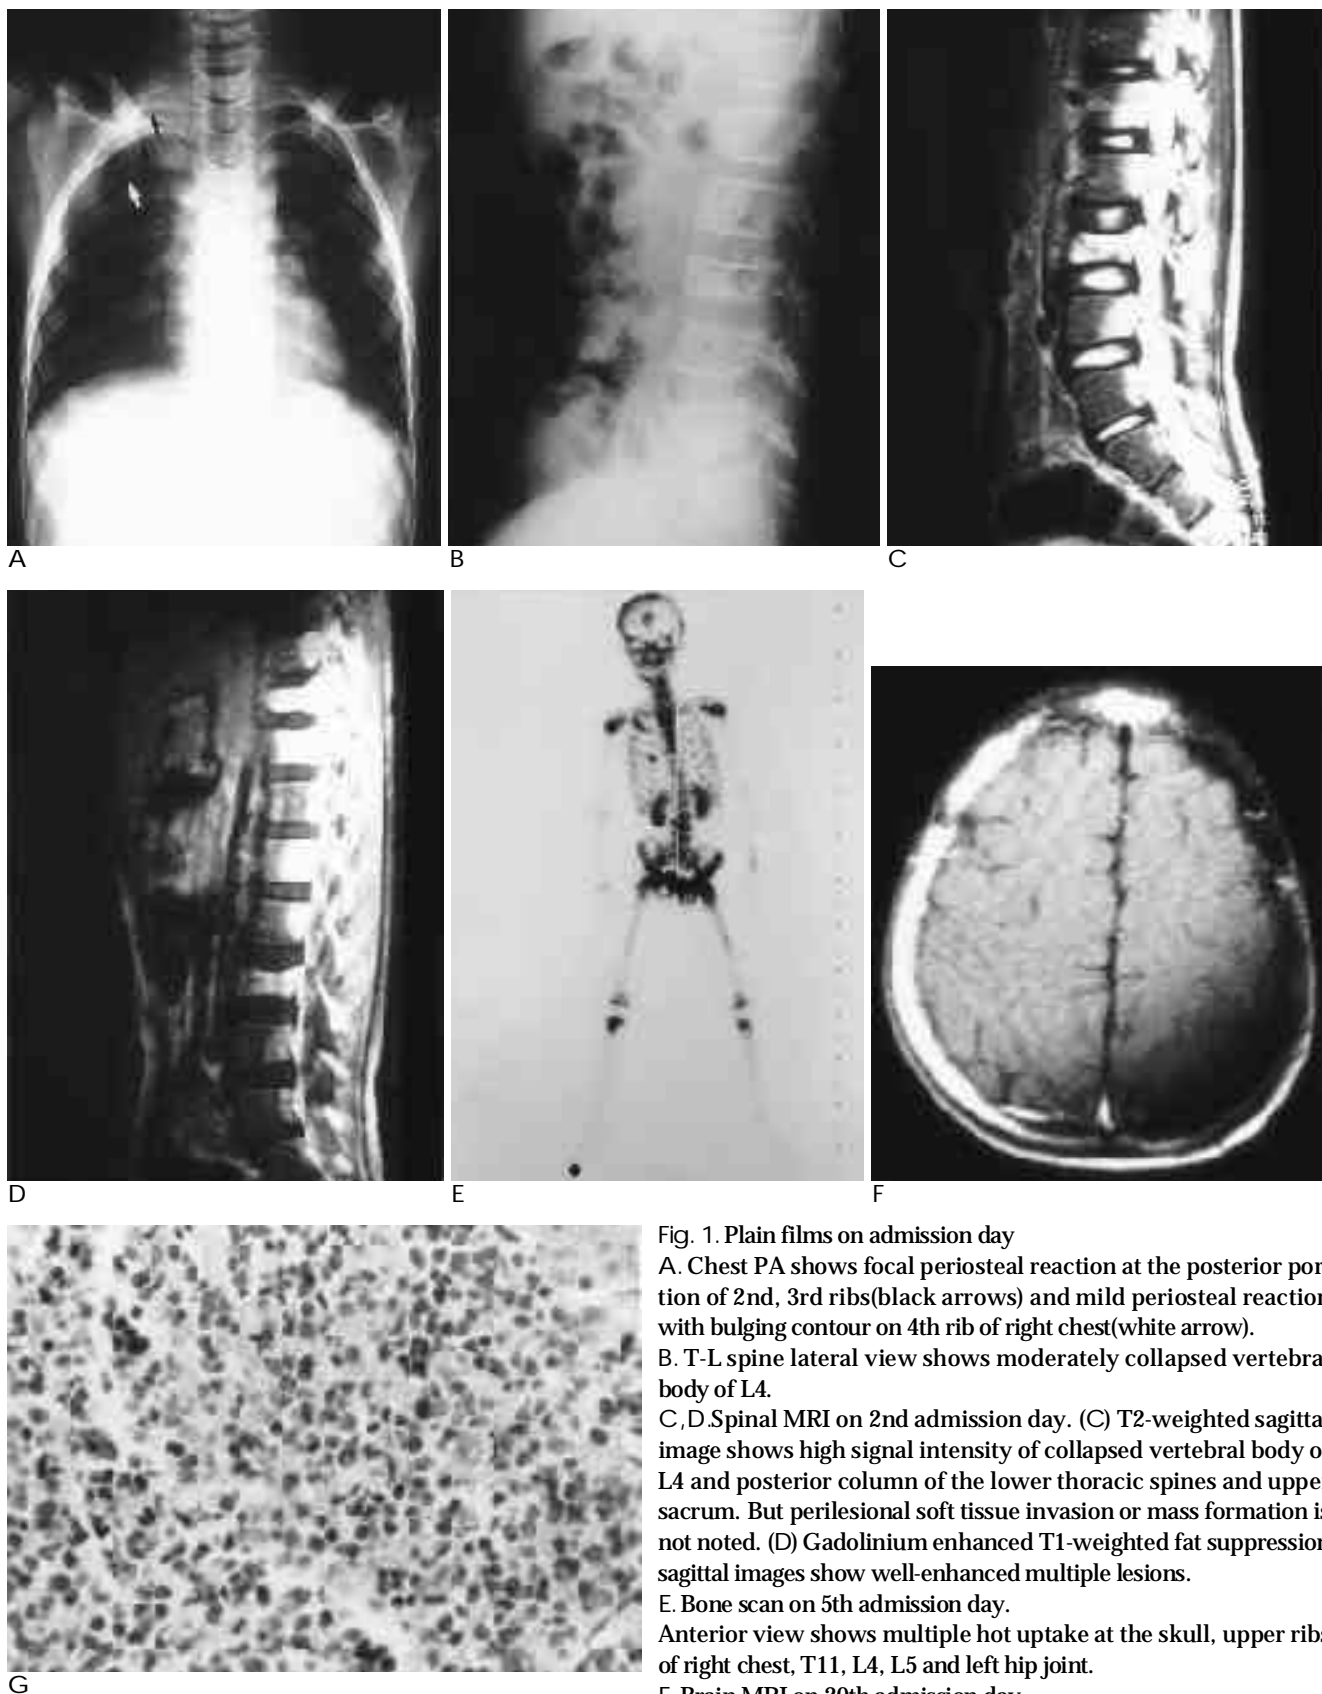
Plain films on admission day
